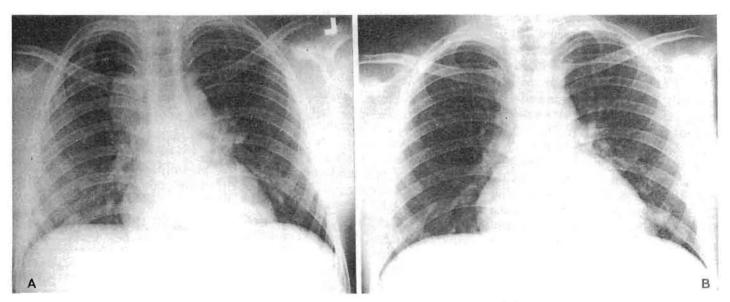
A Chest radiograph on admission showing right paratracheal and bilateral hilar lymphadenopathies.
